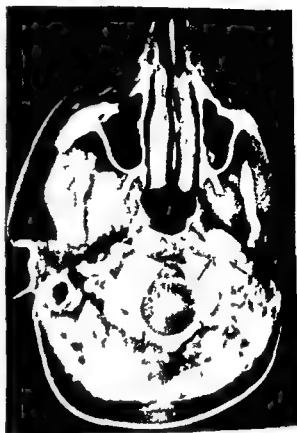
CT of the superior and mid-cervical regions (Courtesy of Dr B Steed Calgary General Hospital Canada). a) An isodense, well-defined mass (→) anterior and to the left of the body of C1. b) Contrast enhancement. The mass (→) is more evident displacing the internal carotid artery (↔) anteriorly.
